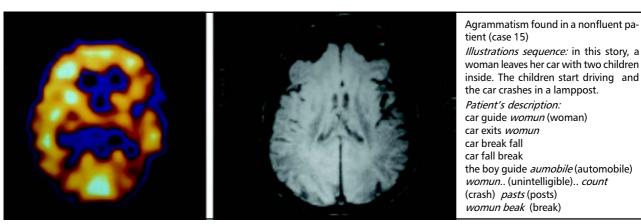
Case 15 - SPECT and MRI showing mild hypoperfusion and atrophy in left fronto-temporal region
